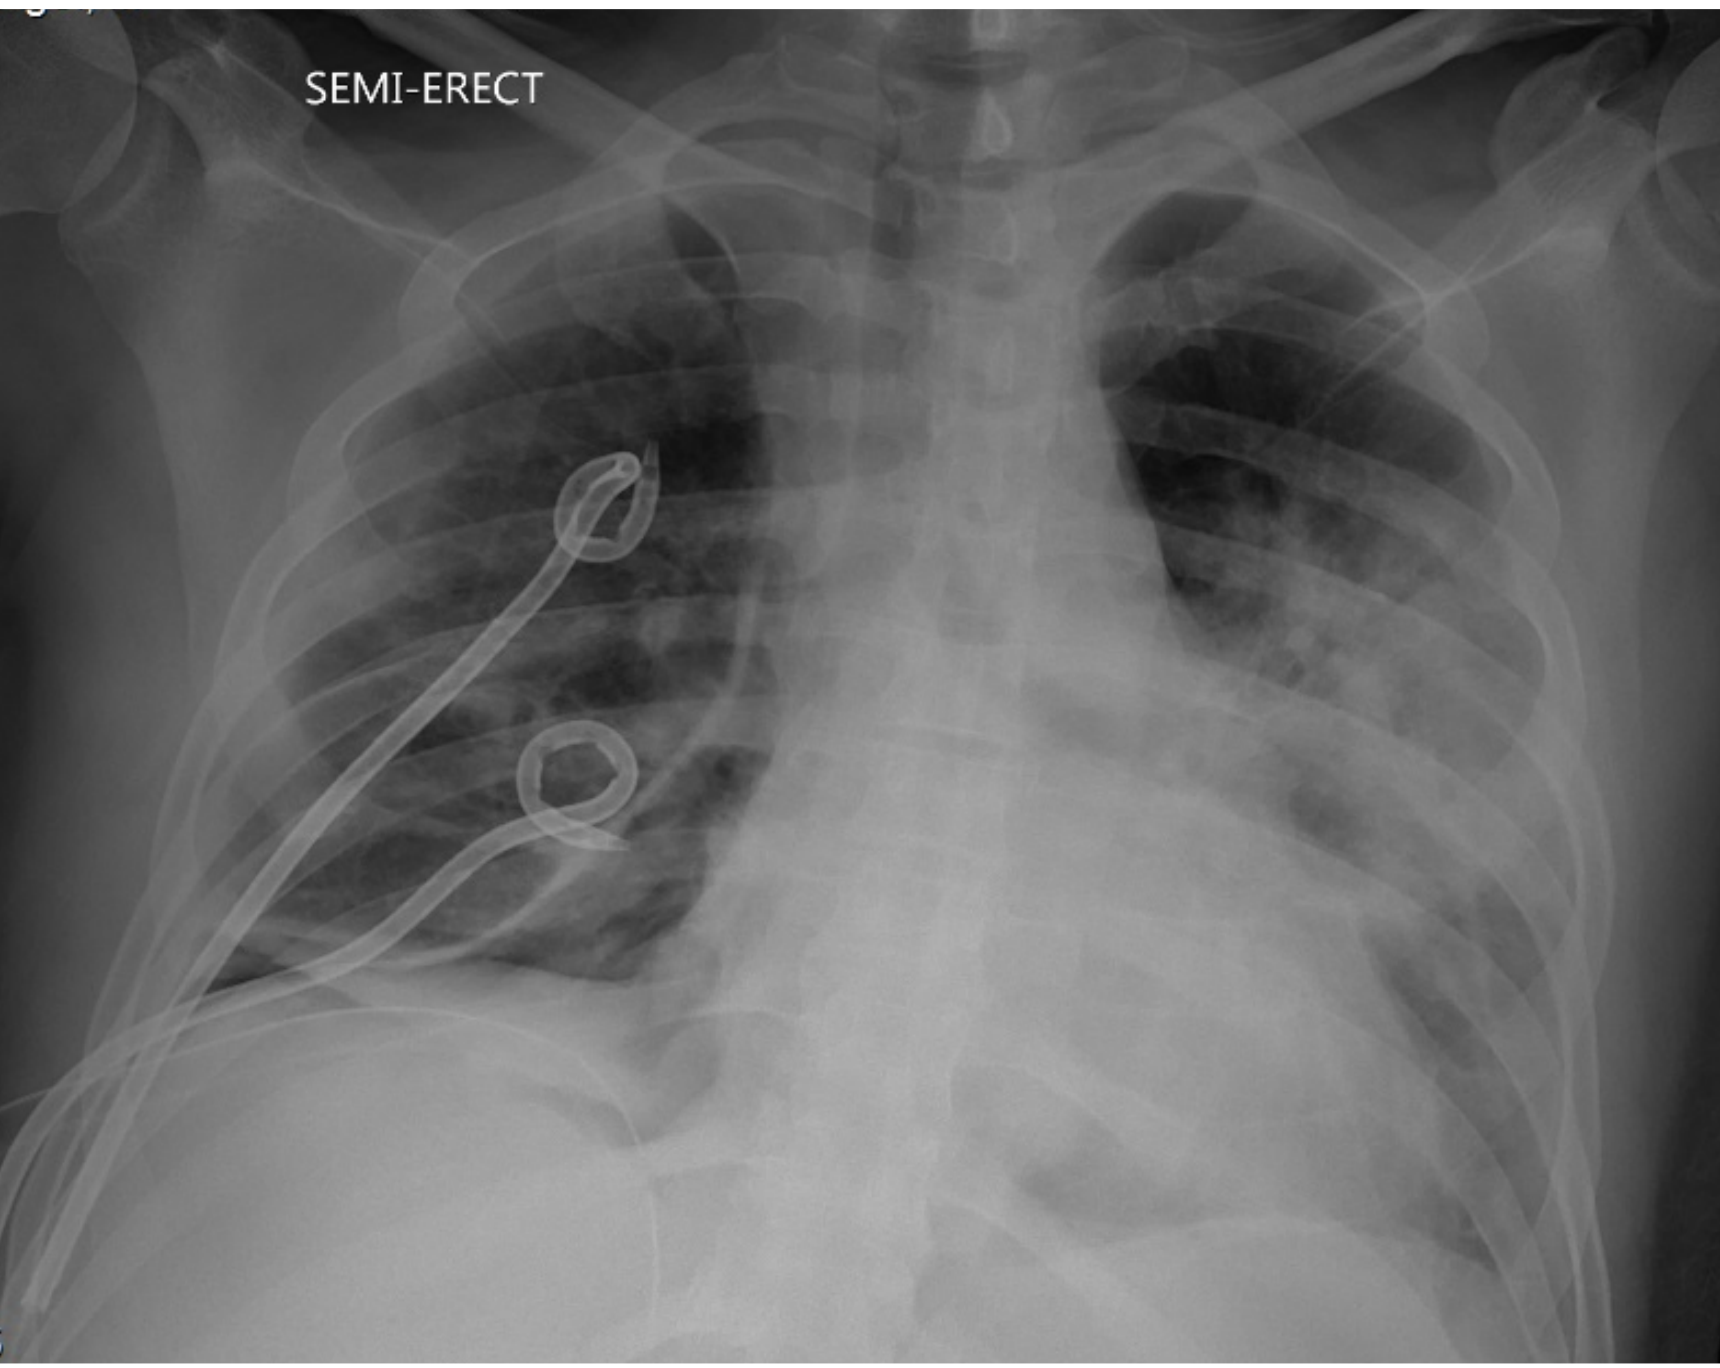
Anterior-Posterior (AP) chest x-ray demonstrating two 14F pigtail thoracostomy tubes in right hemithorax.
